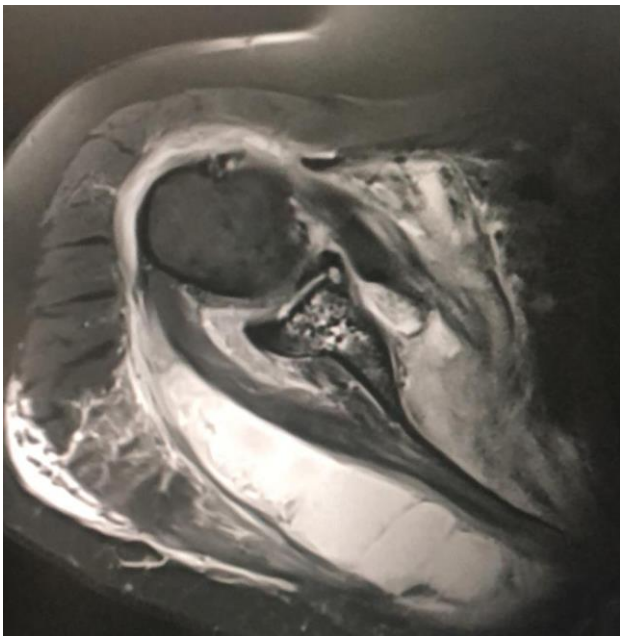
MRI T2W image of the right shoulder joint showing pus collection around subscapularis muscle.
